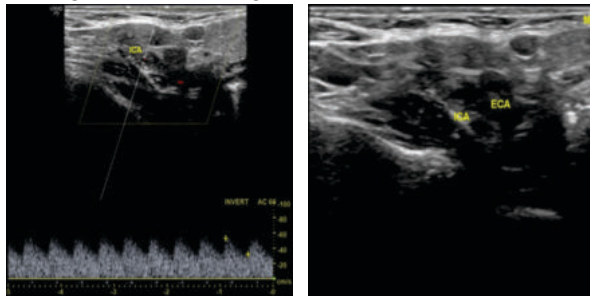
CASE 2: Ultrasound shows involvement of the internal and external carotid arteries with preservation of flow parameters.
